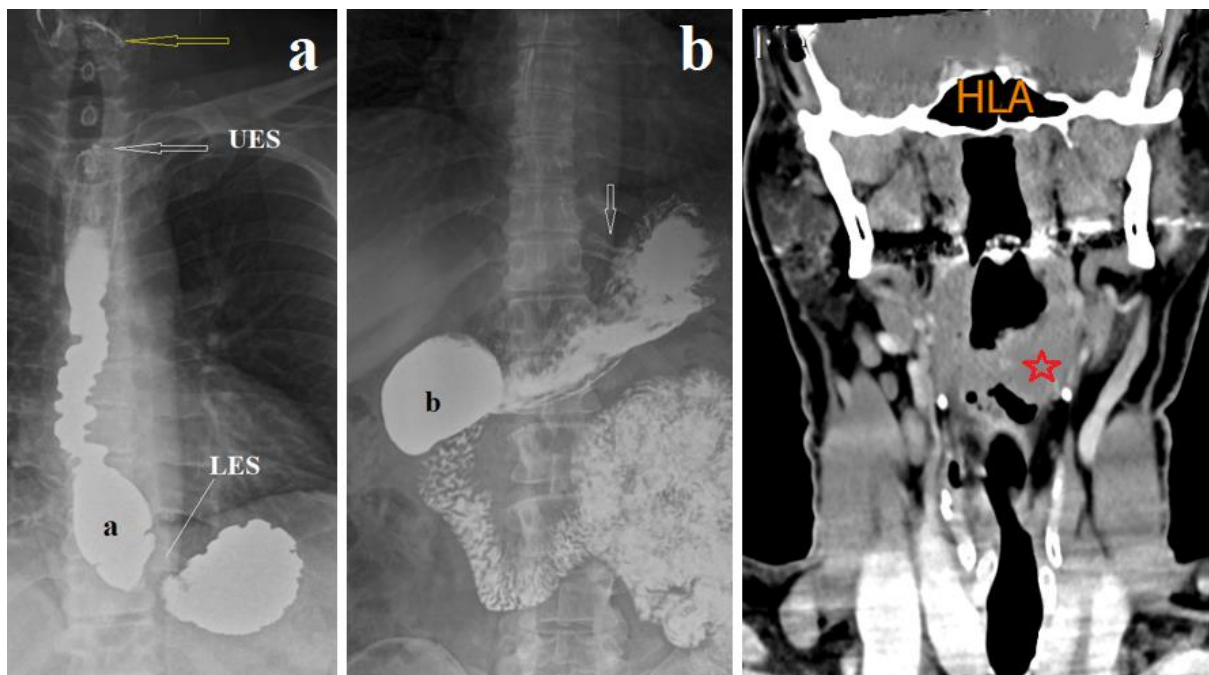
(a) In frontal radiography, the distance between the phrenic ampulla (a) and the stomach, which does not contain contrast, is the contracted LES. Its length is 1.6 cm, approximately 2 cm shorter than normal. The ampulla width is 3.2 cm. The contours of the esophagus are tortuous and asymmetrical, indicating dyskinesia due to esophagitis. The upper
